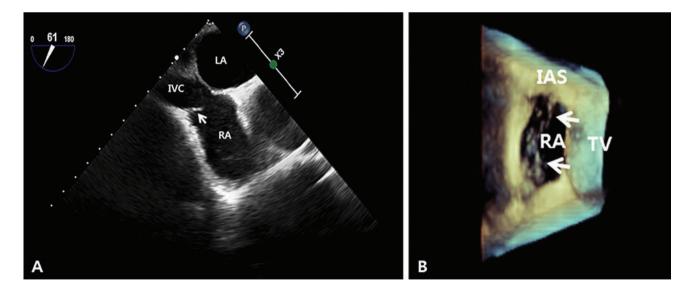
(A) Two-dimensional transesophageal echocardiography (TEE) showing a linear structure in the right atrium (arrow). (B) Three-dimensional TEE clearly showing a net-like structure connected to the edge of the IVC and interatrial septum. IAS: interatrial septum; IVC: inferior vena cava; LA: left atrium; RA: right atrium; TV: tricuspid valve.
